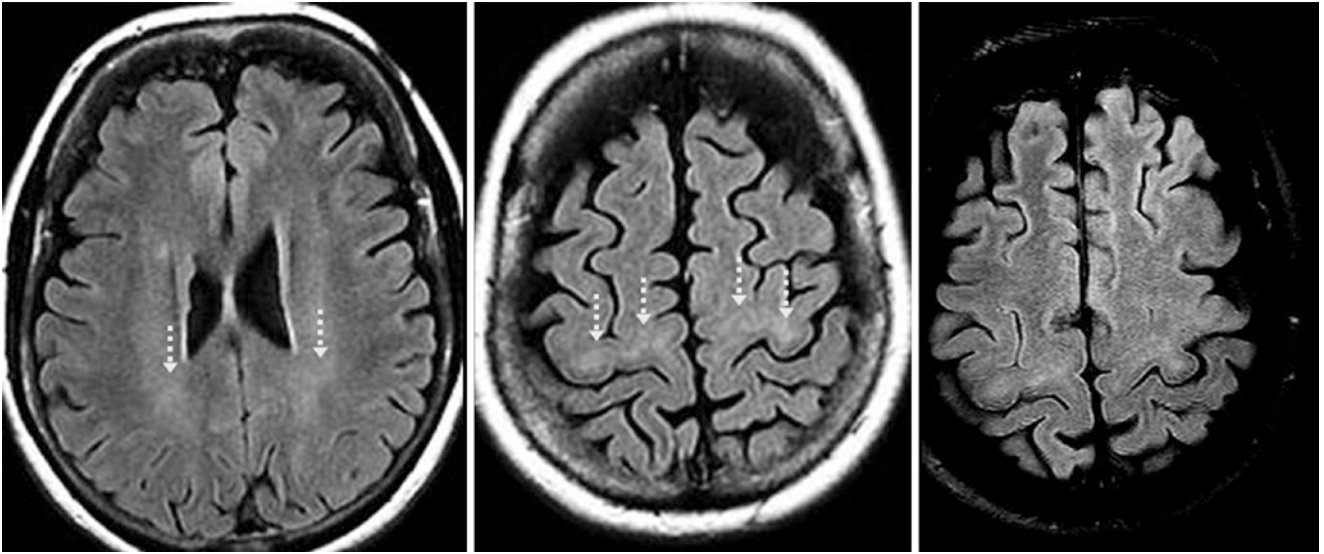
Comparison case of amyotrophic lateral sclerosis (ALS). A 54-year-old with progressive motor weakness underwent a 3 T MRI. FLAIR images (*left and middle*) demonstrated subtle abnormal signal within the posterior PVWM (*dotted arrows*), which extended
